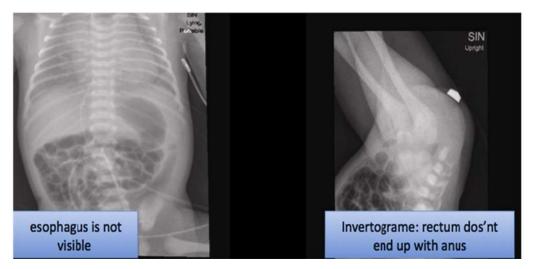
X-ray image of abdominal cavity and thorax (gastric tube ends up in stomach) and invertograme
